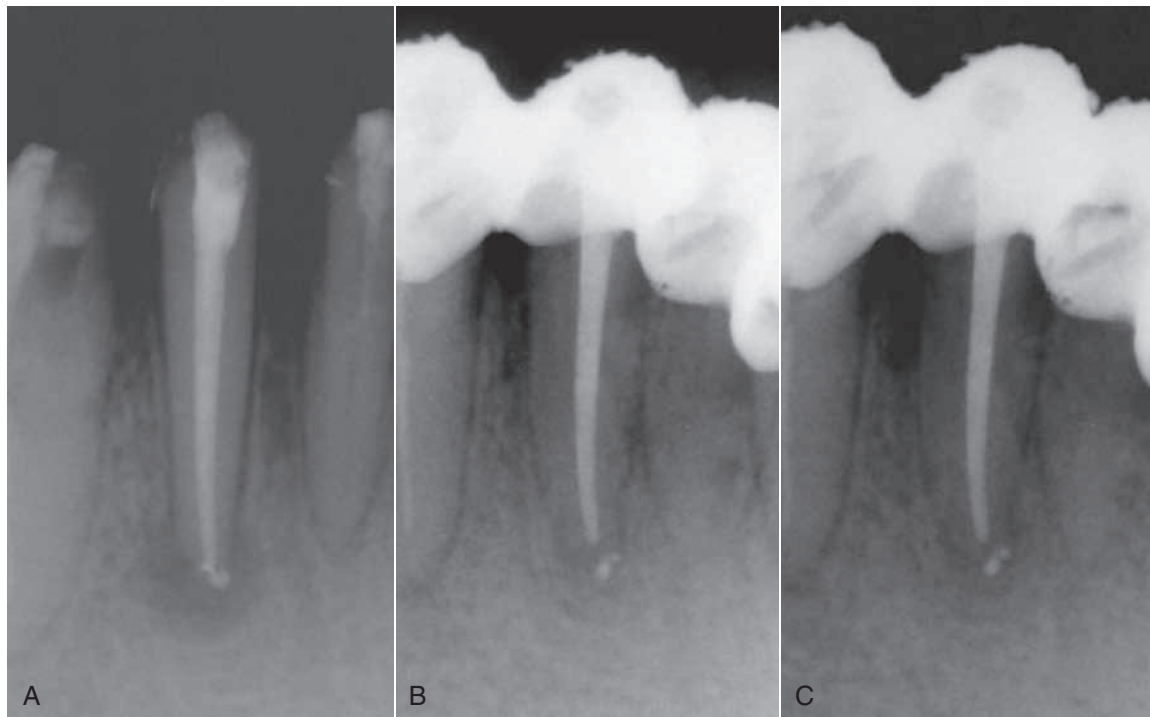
Periapical healing after the Apexum procedure. A, Immediate postoperative radiograph. Note the periapical lesion. B, Three-month follow up. C, Six-month follow-up.²⁵⁸ (Courtesy Apexum, Or-Yehuda, Israel.)
